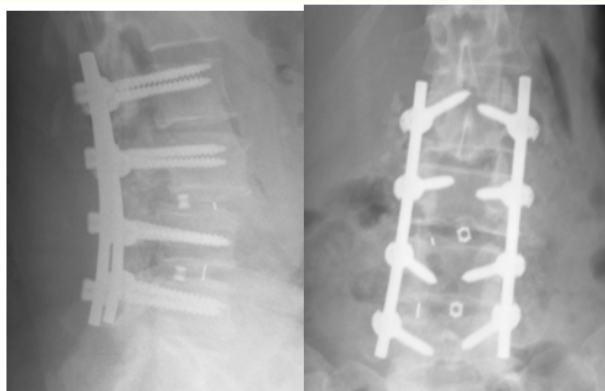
Postoperative lumbar spine X-ray (AP and Lateral view).
